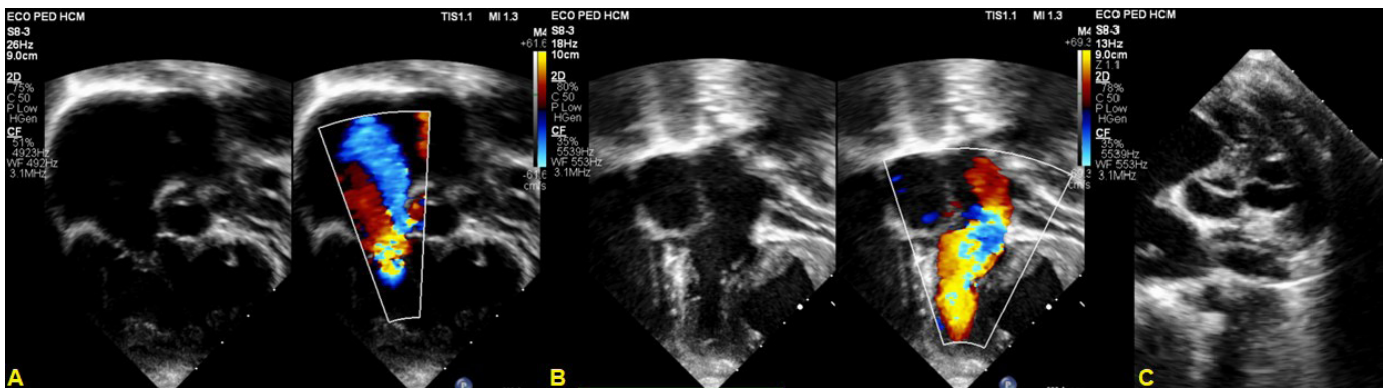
Preoperative echocardiogram. A) Apical image: right ventricle with axis rotation and tricuspid valve insufficiency. B) Apical image: left ventricle crossing the inlet of the right ventricle. C) High short-axis parasternal view: ventriculoarterial valves side by side.
